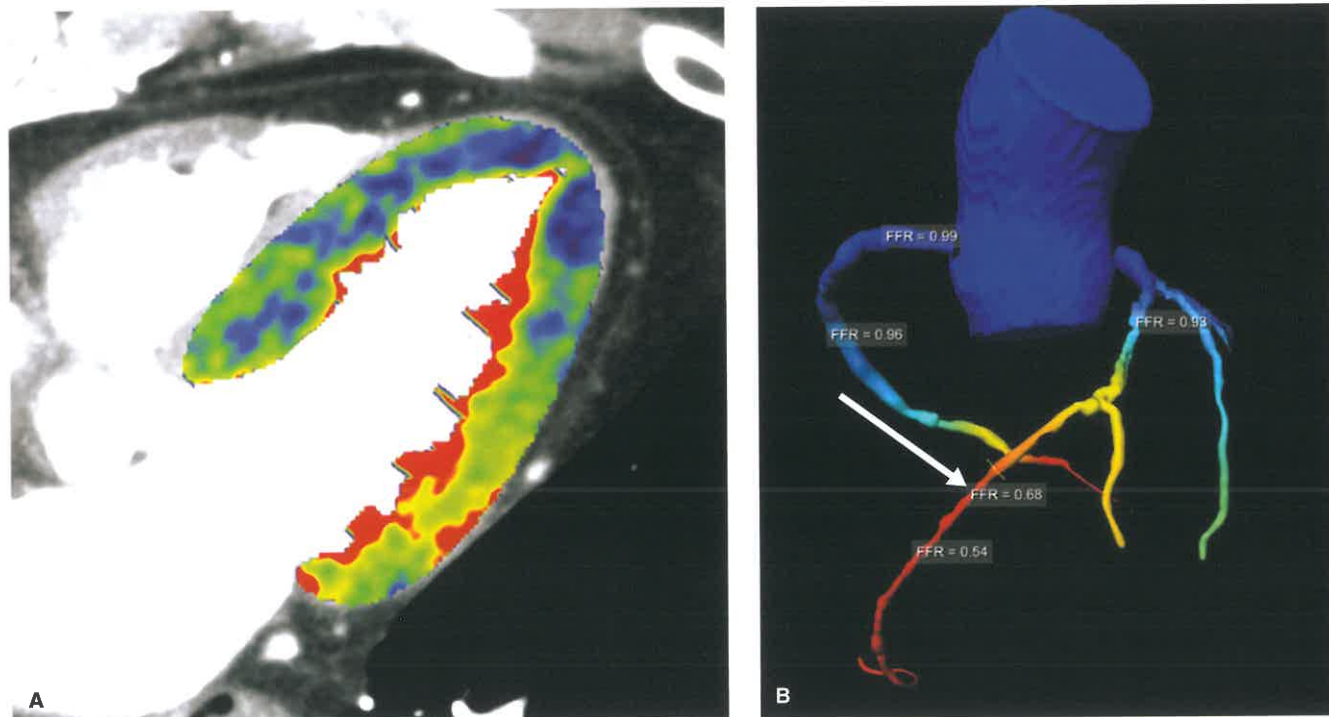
Myocardial Perfusion Imaging and CT-FFR in a 75-Year-Old Man With Episodic Chest Pain. A: Four-chamber image from a stress perfusion CT shows hypoperfusion (*blue pixels*) in the septum and apex consistent with LAD territory ischemia. The rest perfusion study was normal. B: CT-FFR image from the same patient shows significantly reduced flow in the mid and distal LAD (*white arrow*), with CT-FFR values less than 0.8. Flow in the LCx and RCA territories is normal. The patient underwent stenting of his LAD. (Images courtesy of Joseph Schoepf, MD.)
